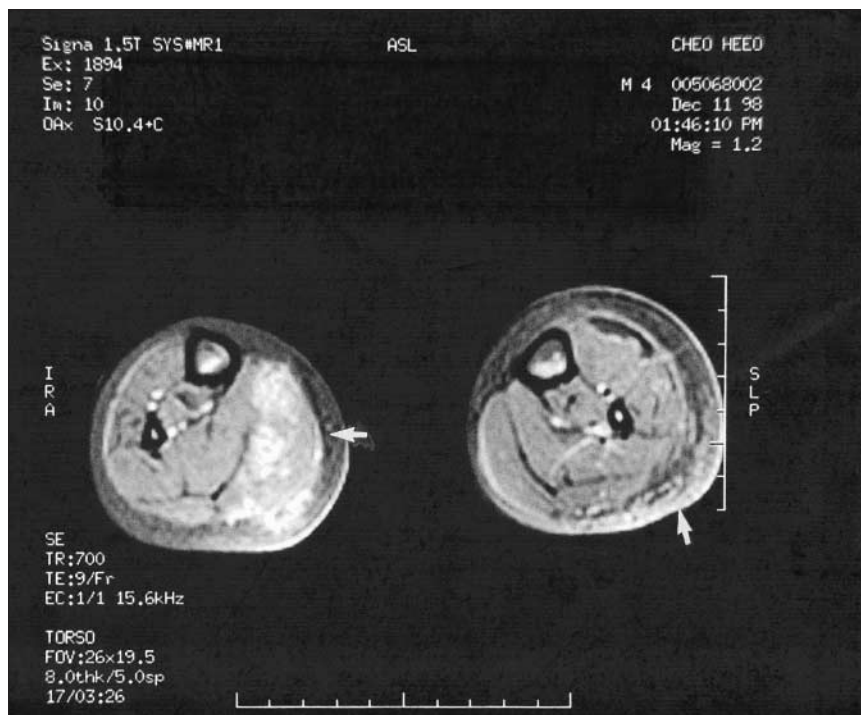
Magnetic resonance image showing the typical appearance of necrotizing fasciitis (arrows) affecting both lower extremities in a 4-year-old boy (case 4). Diffuse muscle infiltration can be seen.
